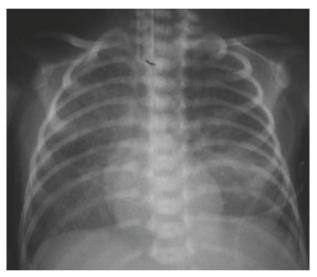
Chest radiograph taken on the third day of life, showing reticular nodular pattern infiltration.
